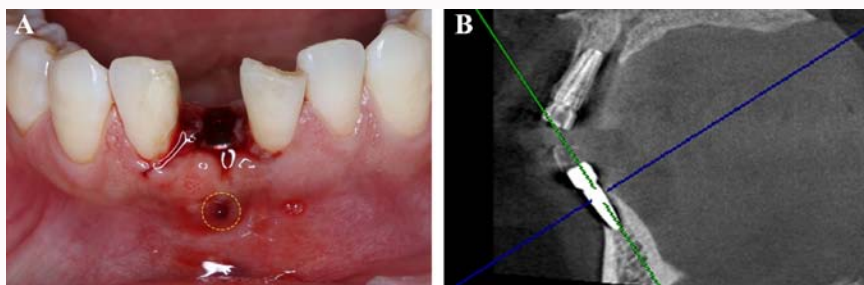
A) Pre-operation clinical examination of the patient. B) CBCT of the patient.
